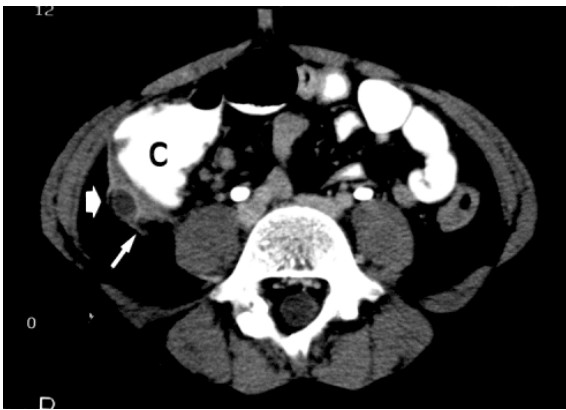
Acute appendicitis. CT image demonstrating a swollen, retrocaecal appendicitis with a rim-enhancing wall (arrowhead). There is stranding of the peri-caecal fat (arrows). c = caecum.
